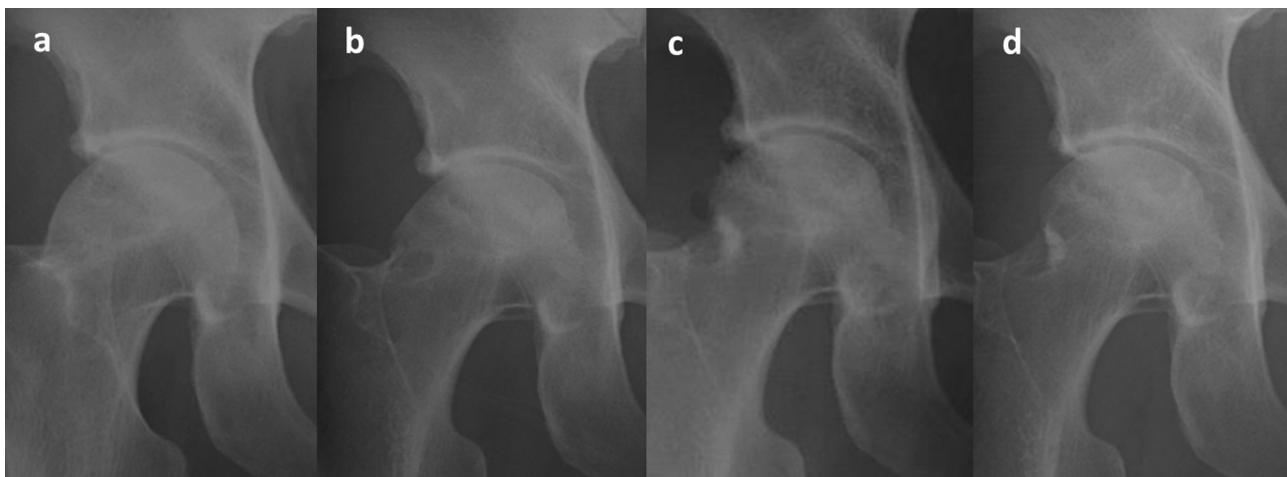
Anteroposterior radiographs taken (a) 4 years before the arthroscopic surgery, (b) just before surgery, (c) immediately after surgery, and (d) 3 years after surgery. No obvious progression of joint-space narrowing has been seen in the 7 years.
